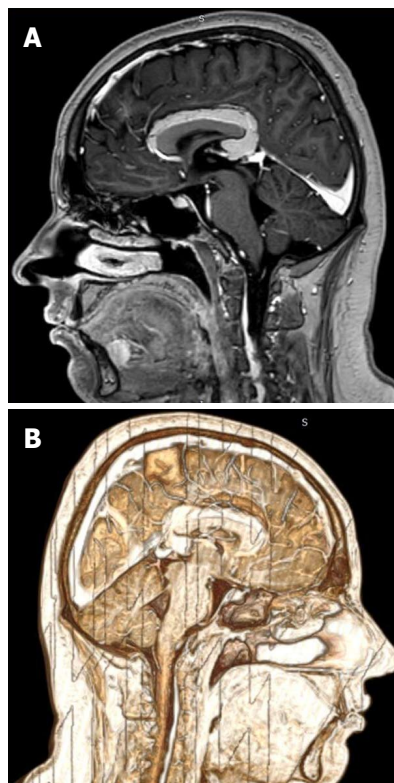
T1-W 3D TFE + MDC magnetic resonance imaging. A: Showing the relationships between vasculature, corpus callosum, lipoma and adjacent brain tissues; B: Showing the pericallosal lesion, compatible with a complete curvilinear lipoma without callosal aplasia.
